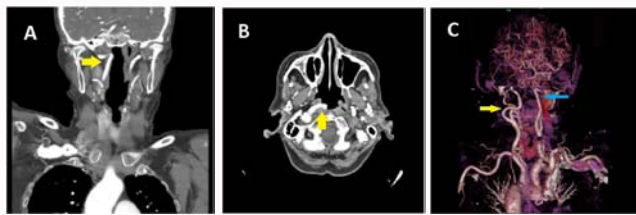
A) Coronal cross-sectional CT image of the right-sided nasopharynx (yellow arrow). B) Axial cross-sectional CT image of the right aberrant ICA in the nasopharynx (yellow arrow). C) CT angiography showed a bent ICA on the right posterior view (blue arrow), a curved ICA image on the left (yellow arrow).
